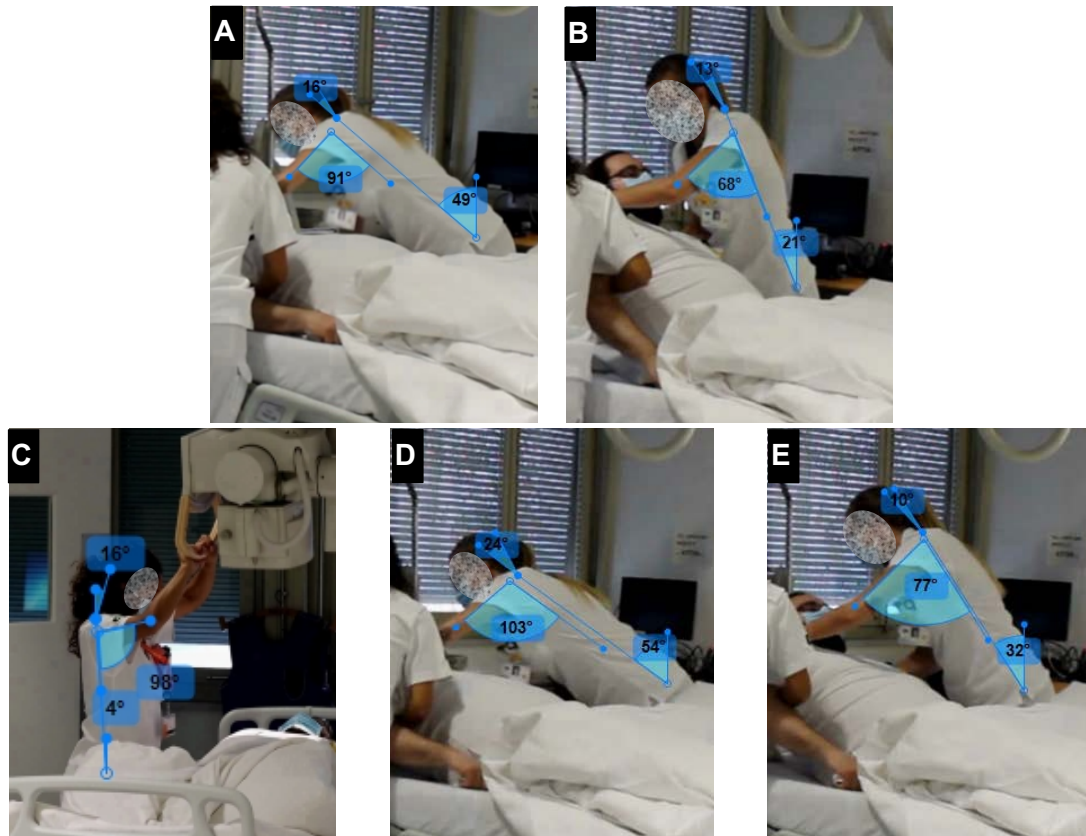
"Not acceptable" postures assumed by the shorter (performer) and medium (helper) radiographers during bedside chest X-ray examination in scenario 6: a) the medium radiographer during the preparation to position the detector under the patient's back; b) medium radiographer during the patient handling to position the detector under the patient's back; c) the shorter radiographer during the X-ray tube positioning; d) the medium radiographer during the preparation to remove the detector from under the patient's back; e) the medium radiographer during the patient handling to remove the detector from under the patient's back.
